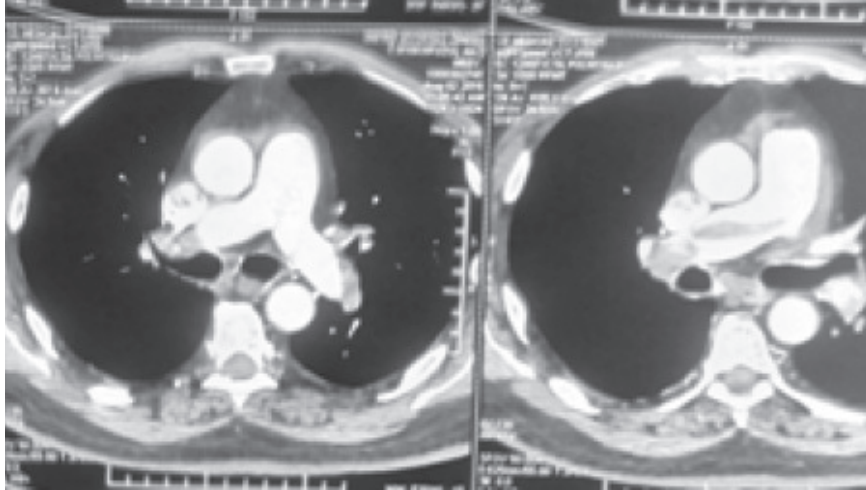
CT pulmonary angiography showed thrombus at right pulmonary artery After thrombolysis*
